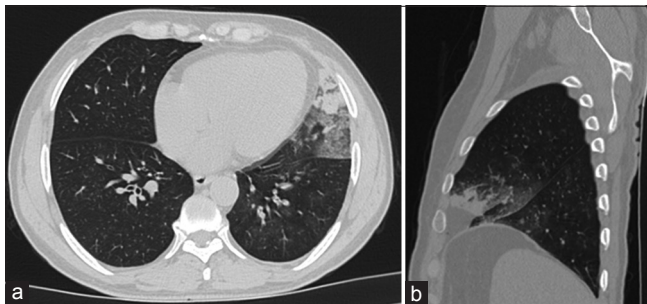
(a) Axial and (b) Sagittal HRCT images showing consolidation in the left lingular segment in case of bacterial infection
